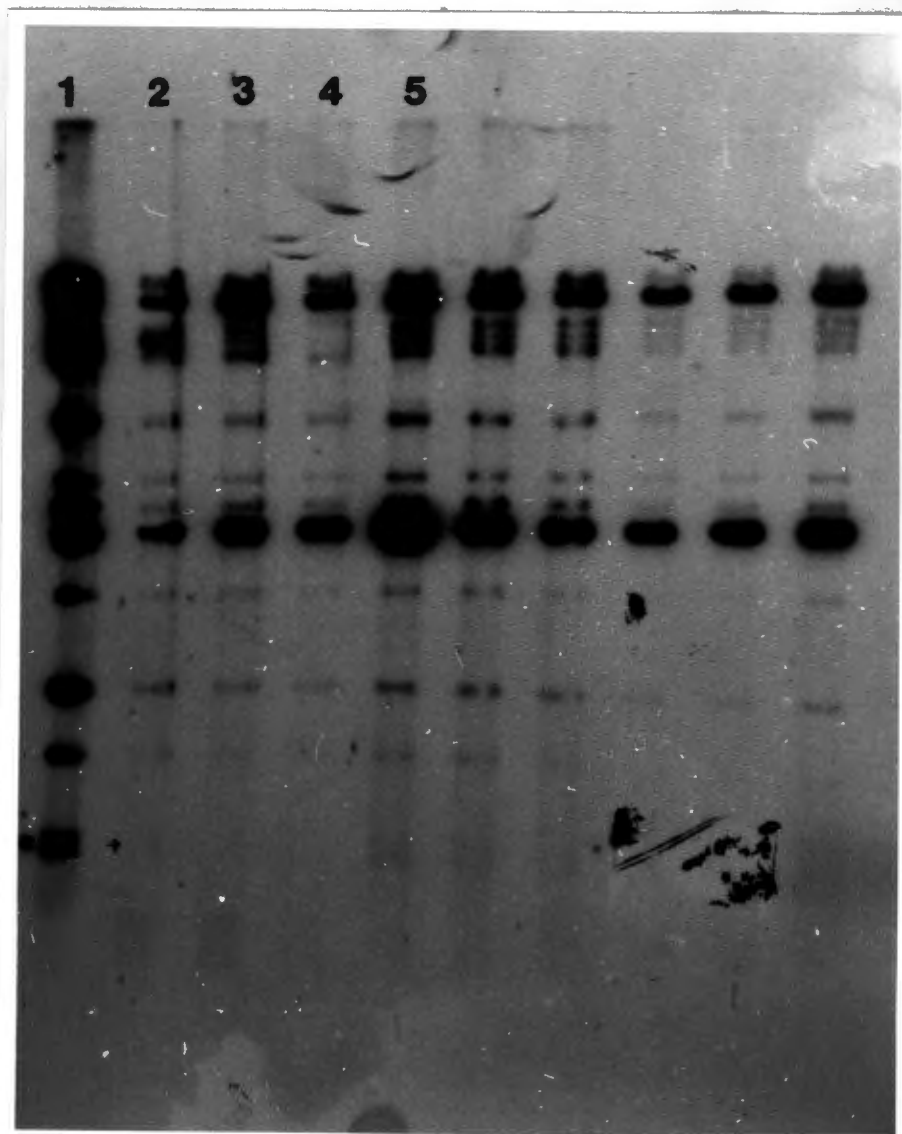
Autoradiograph of ^{32}P -labelled Mp Denmark Pst I fragments hybridized to a Mp Denmark Hind III blot (deca-probe apparatus). Lanes 1 - 5. 1: Mp Denmark Pst I whole genome; 2: Pst I M; 3: Pst I N; 4: Pst I P; 5: Pst I Q. The probes leaked between hybridization chambers, lighting up in lanes that were not in use. Signals of high intensity were considered to be real. The X-ray film was exposed for 8 hours.
